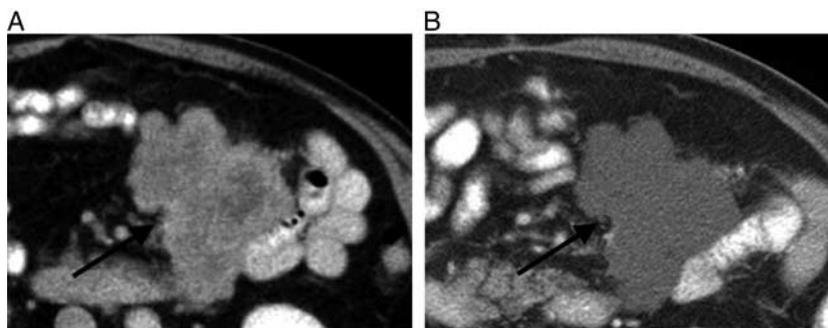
Choi criteria: gastrointestinal stromal tumor (GIST) and imatinib use. A, Baseline contrast-enhanced axial CT image shows mesenteric GIST (black arrow), which is heterogeneously hyperattenuating before therapy. B, Follow-up contrast-enhanced axial CT image obtained after 4 months of imatinib shows no change in the size of lesion; however, the lesion is now homogeneously hypoattenuating with marked reduction in attenuation from baseline, suggestive of internal necrosis and treatment response.
